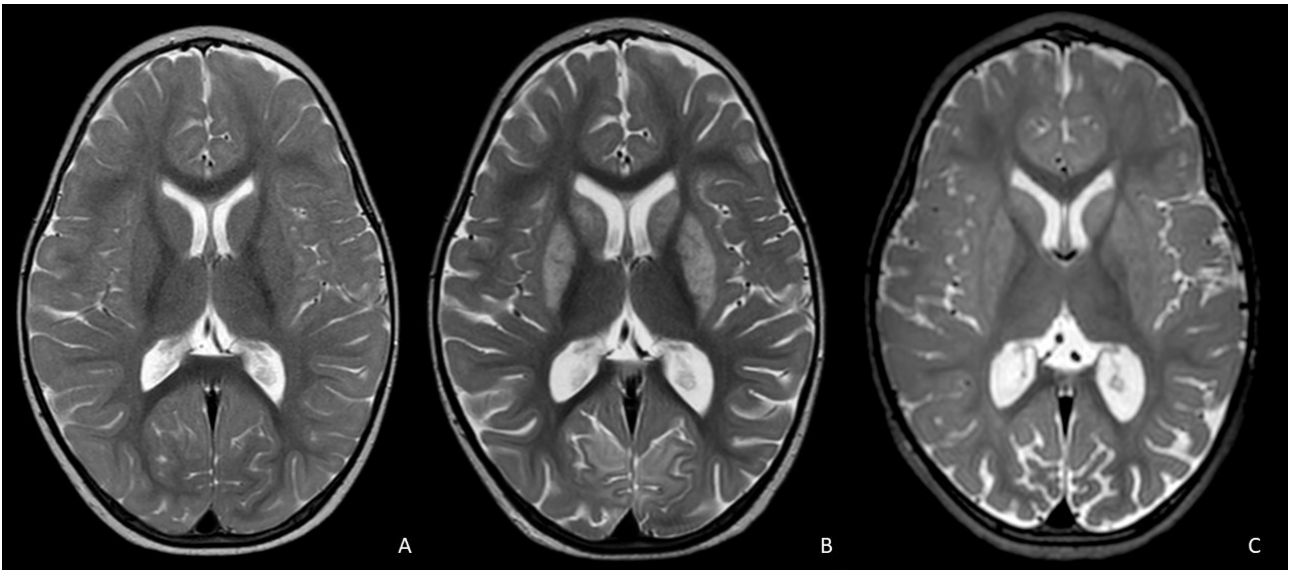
Brain MRI evolution after citalopram intoxication. A) normal second day brain MRI; B) bilateral caudate and putamen hyperintensity, associated to an occipital cortical and subcortical hyperintensity, similar to PRES at 18th day hospitalization; C) basal ganglia, and bilateral subcortical parieto-occipital white matter hyperintensities reduction without volumetric modifications. Moderate cortical-subcortical bilateral thinning of the parieto-occipital regions with ex-vacuo ventricular enlargement.
